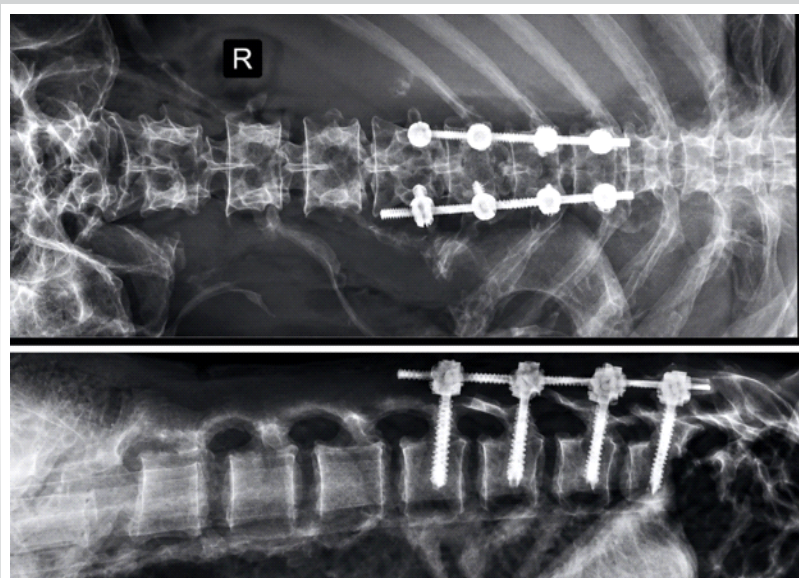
Six-month follow-up. Anteroposterior and lateral radiographs demonstrating maintained reduction, satisfactory implant position, and no evidence of construct failure. Patient-identifying information has been removed from all images.
